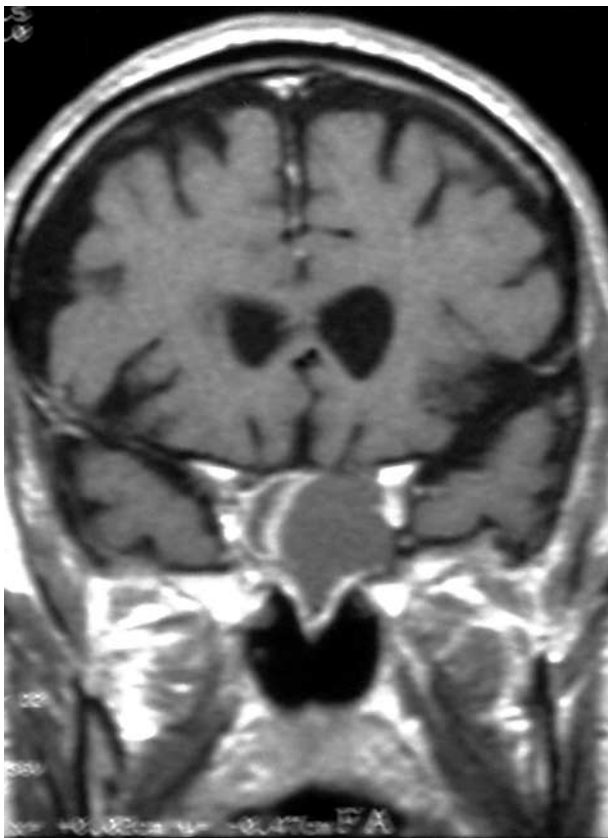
Preoperative coronal MRI showing left sphenoid sinus filled by hypointense material with contrast enhancement.
